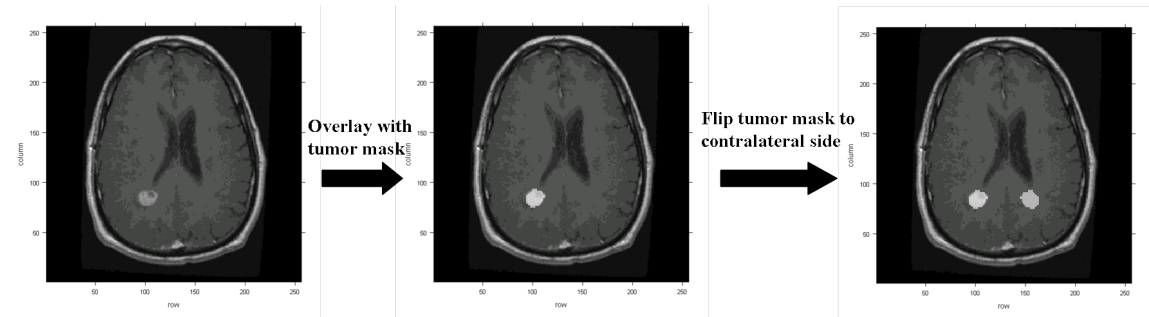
Obtaining the healthy tissue ROI. Left image: original T1-weighted contrast enhanced MRI; Middle image: overlay the original MRI with tumor mask to obtain the tumor region of interest; Right image: mirror the tumor mask to the contralateral hemisphere of the brain to get the healthy tissue region of interest.
